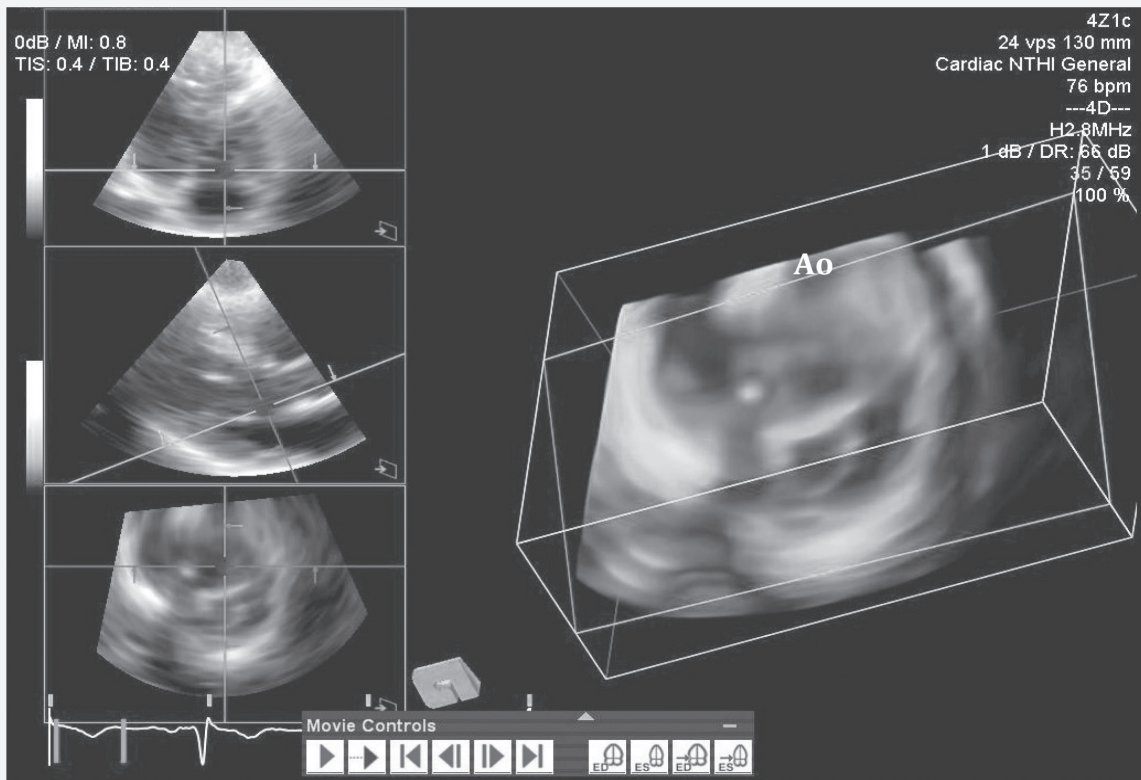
Transthoracic 3D echocardiography en-face view of the two mitral valve orifices from left ventricular perspective showing a “figure-of-8” configuration. This image demonstrates how the multiplanar capability of 3D allows visualization of structures from unconventional viewing planes not possible with 2D. Abbreviations: 2D, two-dimensional; 3D, three-dimensional; Ao, aorta.
